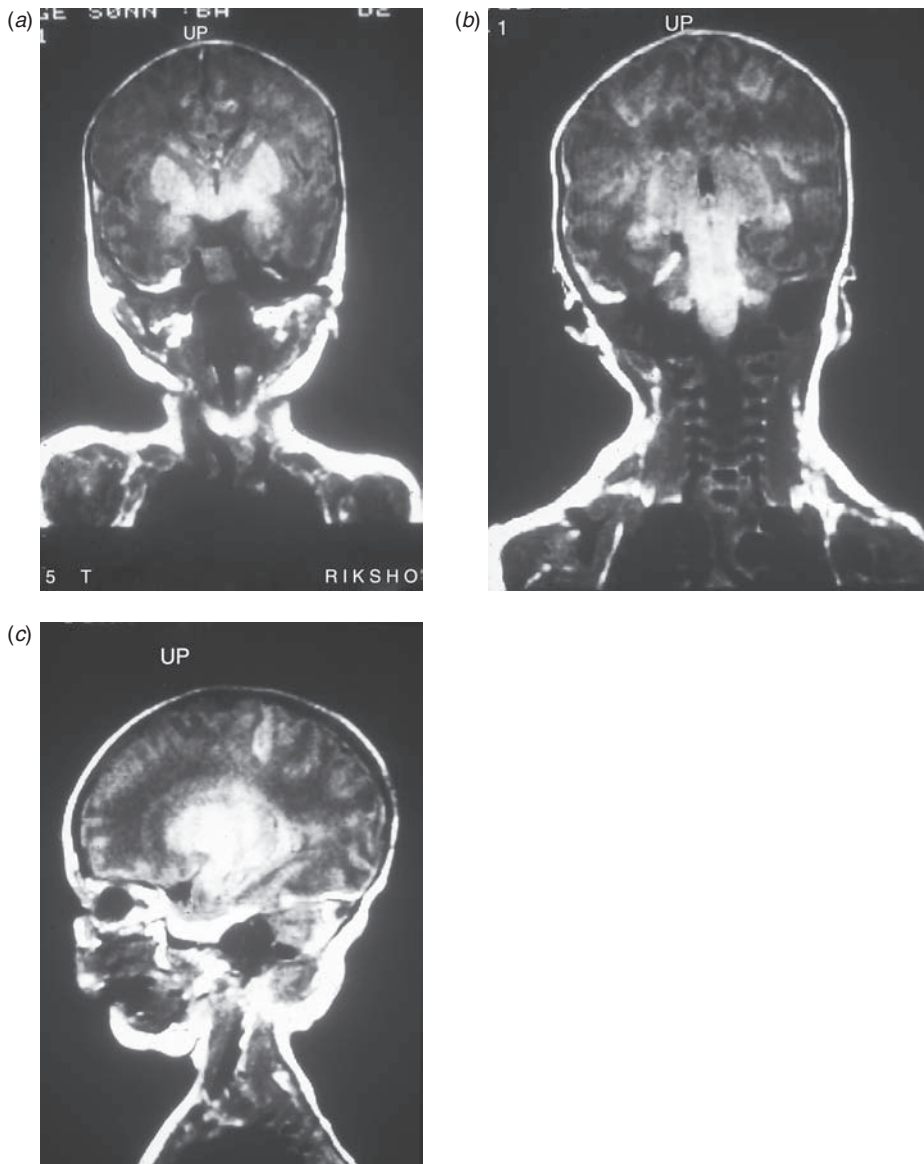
Severe hypoxic–ischemic encephalopathy (same baby as in Fig. 18.4). Cerebral magnetic resonance T1-weighted image. (a) Coronal view: abnormal bright signal in the basal ganglia and thalami. (b) Coronal view: abnormal bright signal in the brainstem and basal ganglia. (c) Sagittal view: abnormal bright signal in basal ganglia and thalamus.
